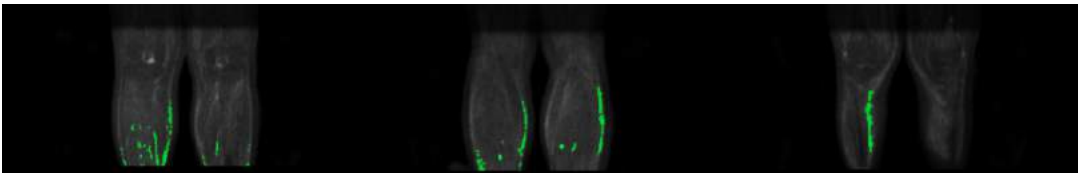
Several coronal representative slices of the legs of Case 16 (male), using the connected-component segmentation applied to the 1000 s/mm² image. The segmented areas are hyperintense on DWI and 35% darker than the muscle on T1w. However, it is easily seen that these areas are not near the skeleton, thus would never be mistaken by MM lesions.
